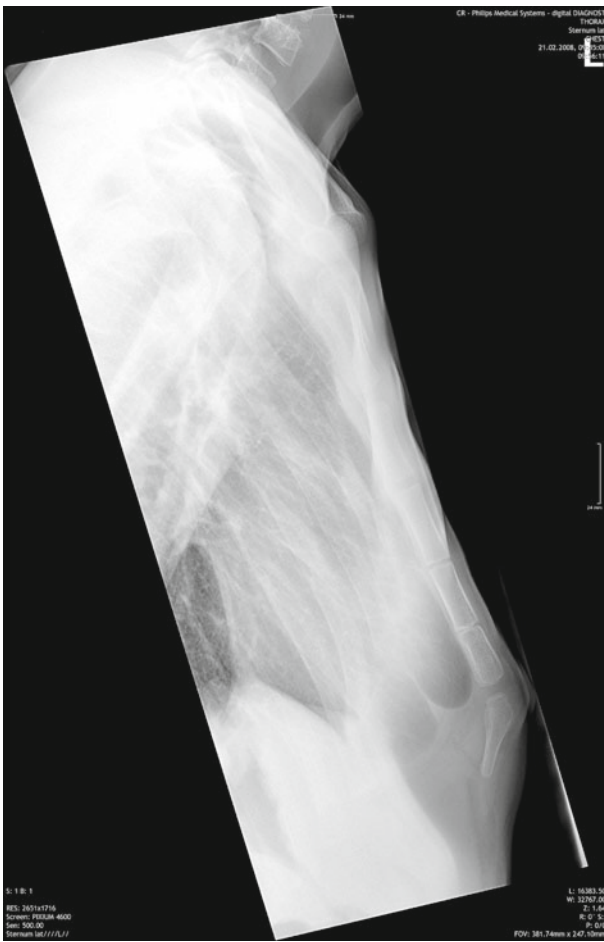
Lateral chest X-ray depicts the situation postoperatively with three horizontal osteotomies performed for remodeling. The lowermost gap represents no osteotomy but a not yet ossified growth zone, already resulting in a tissue protrusion several months postoperatively
